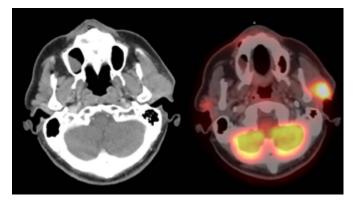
CT and fusion PET-CT image showing metabolically active disease in heterogeneously enhancing enlarged left parotid gland. Standardized uptake maximum value (SUVmax) is 3.5 cm2/ml.
